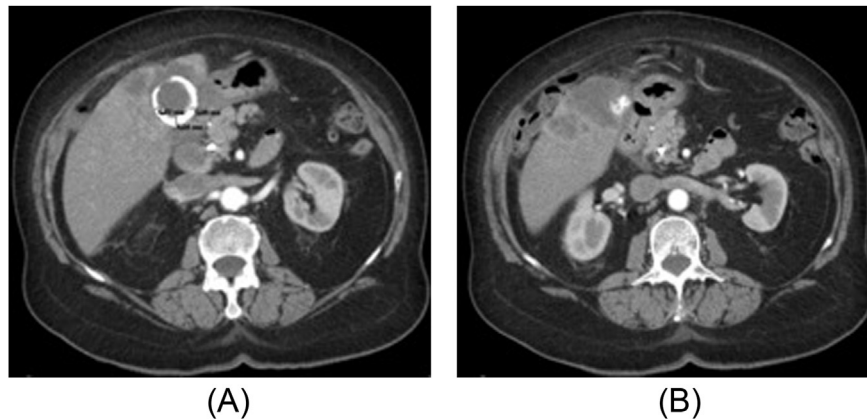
(A) CT showed exophytic growth of a vesicular mass and a calcified wall thickening. (B) Affected liver segments (IV b, V, VII, VIII) extended to the liver capsule, hepatic hilum, and gastrohepatic ligament.
